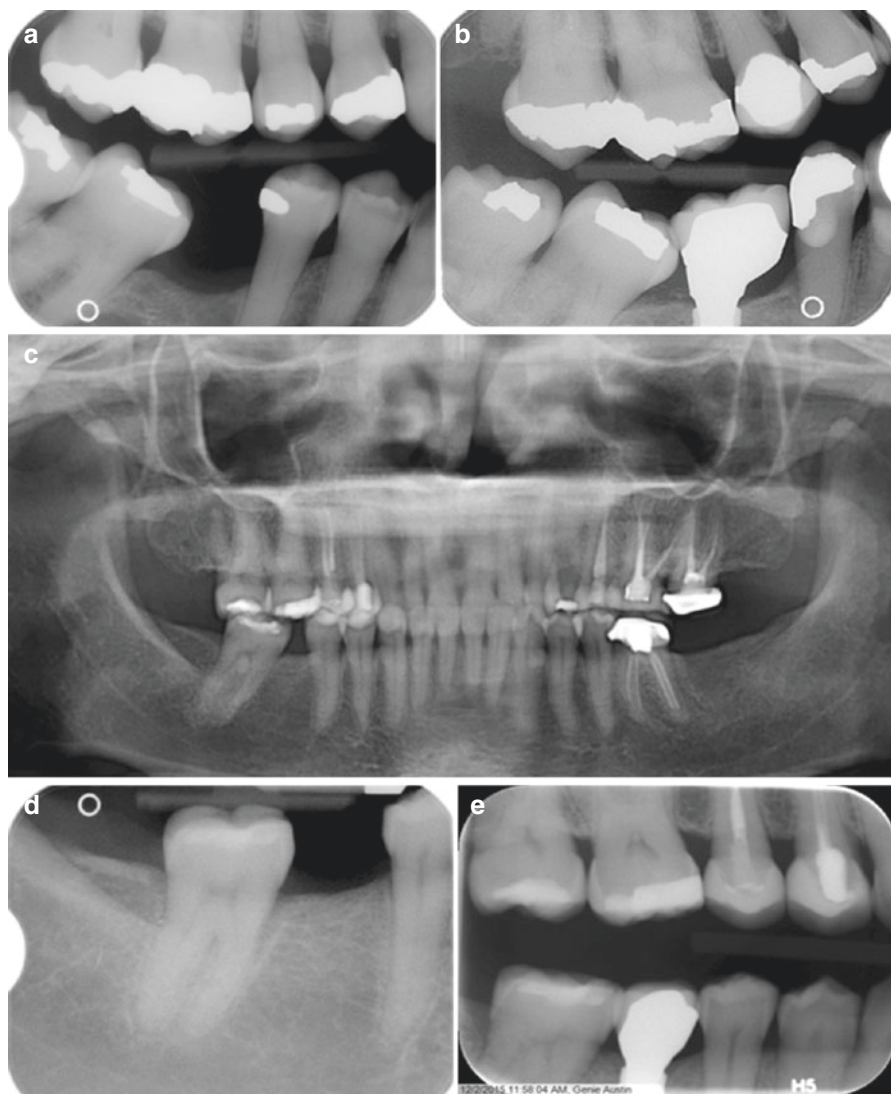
(a) Tipped adjacent tooth can lead to difficulty in implant placement and restoration. (b) Implant crown with less than optimal emergence profile, gingival embrasure size, and interproximal contacts. (c) Panoramic radiograph of a case with mesial drifted first molar limiting the size of the edentulous space. (d) Periapical radiograph after orthodontic correction. (e) Periapical radiograph showing symmetrical implant crown shape exhibiting good emergence profile and smaller gingival embrasures
